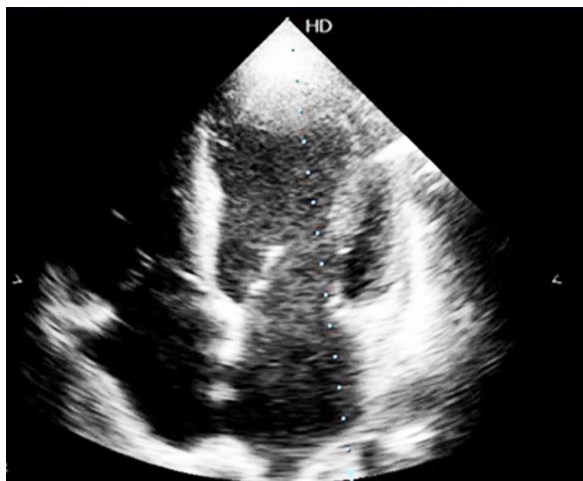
Transthoracic 2D echo showing grossly dilated heart and decreased global biventricular function.
